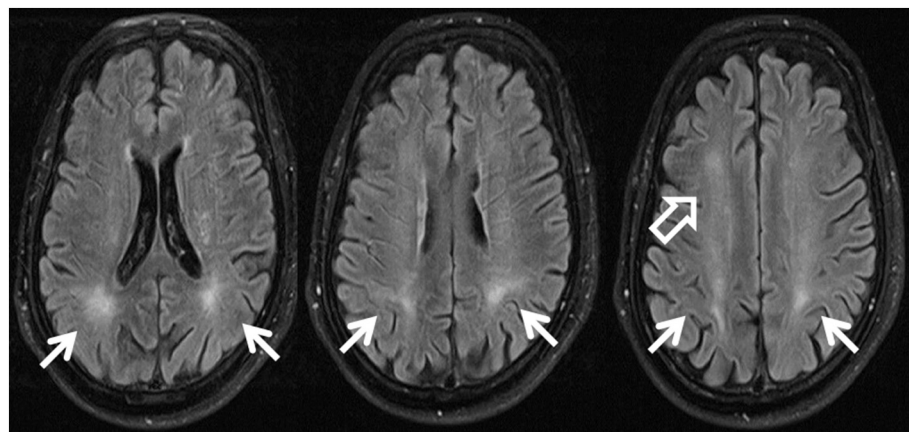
Cranial magnetic resonance imaging (cMRI) in case 1. The patient presented with organic psychosyndrome, unsteady gait, and paraplegia with pyramidal signs. Primitive reflexes were present with positive palmar grasp reflexes. cMRI showed bilateral symmetric hyperintensities in the white matter parietooccipital (white arrows) as well as hyperintensities in the frontal regions more pronounced on the right side (transparent white arrow) on T2-Fluid Attenuated Inversion Recovery (Flair) sequences.
